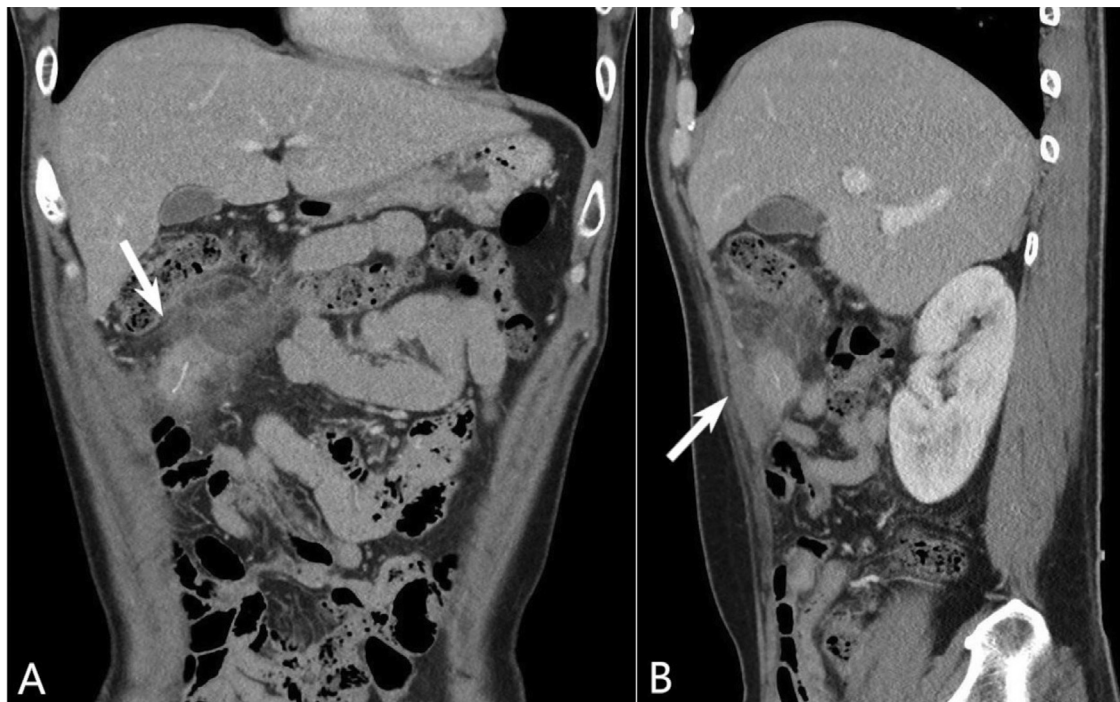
Coronal and sagittal computed tomography scans show a heterogenous area in the omentum in the right upper quadrant. A 2-cm long linear radiopaque material within the enhancing soft tissue density lesion is observed (A). The lesion is in contact with the posterior aspect of the right transversus abdominis muscle, and the muscle is swollen (B, arrow). The lesion also contacts the proximal transverse colon; however, there is no evidence of bowel wall thickening (A).
